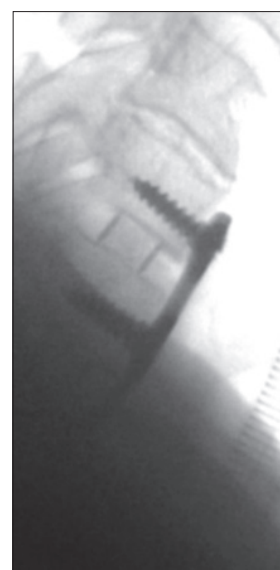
Intraoperative X-ray image, highlighting the difficult visualisation of the Th1 vertebra, with the anterior plate and PEEK cage at C6-C7 visible
